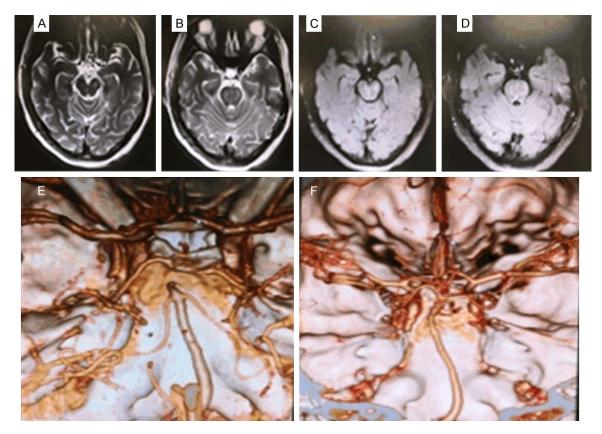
Reversible basilar artery disease caused by antiphospholipid syndrome. A-D: Skull MRI showed pontine, midbrain flaky long T2 signal and Flair high signal; E: CTA before head and neck treatment indicated occlusion of the basilar artery end and initial occlusion of the bilateral posterior cerebral artery; F: CTA after treatment indicated P1 segment of bilateral posterior cerebral artery.
